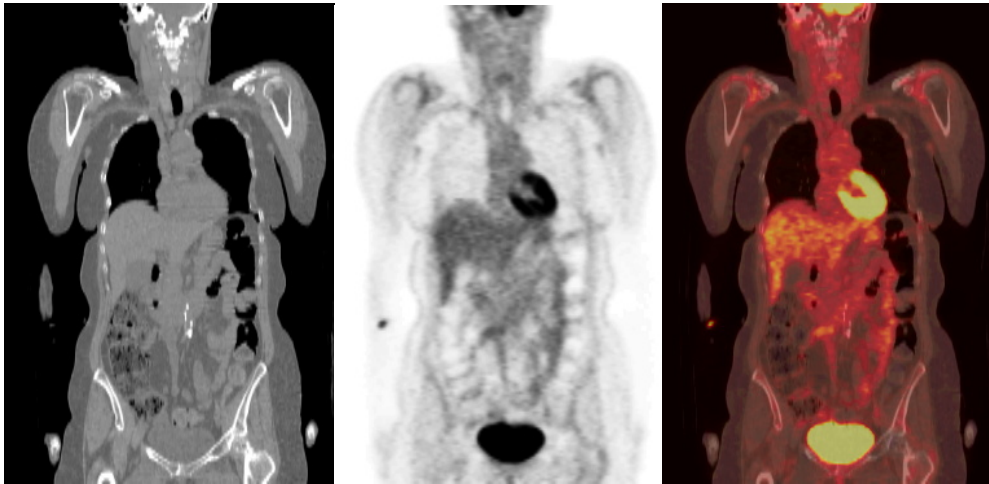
Images from a PET/CT scanner: anatomical CT image (left), functional PET (middle, right, same as Fig. 8 - right), and overlaid images (right) of a whole-body scan.
